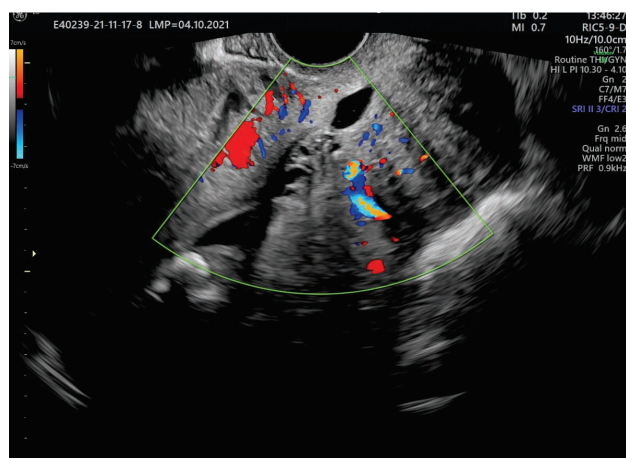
2D transvaginal ultrasound reveals complex lesions of the cervix; Naboth cyst (blue arrow), protrusive smooth surface lesion (orange arrow) and a cervical fibroid with its feeding pedicle (dashed line) (personal collection of Roxana Bohîlțea)
